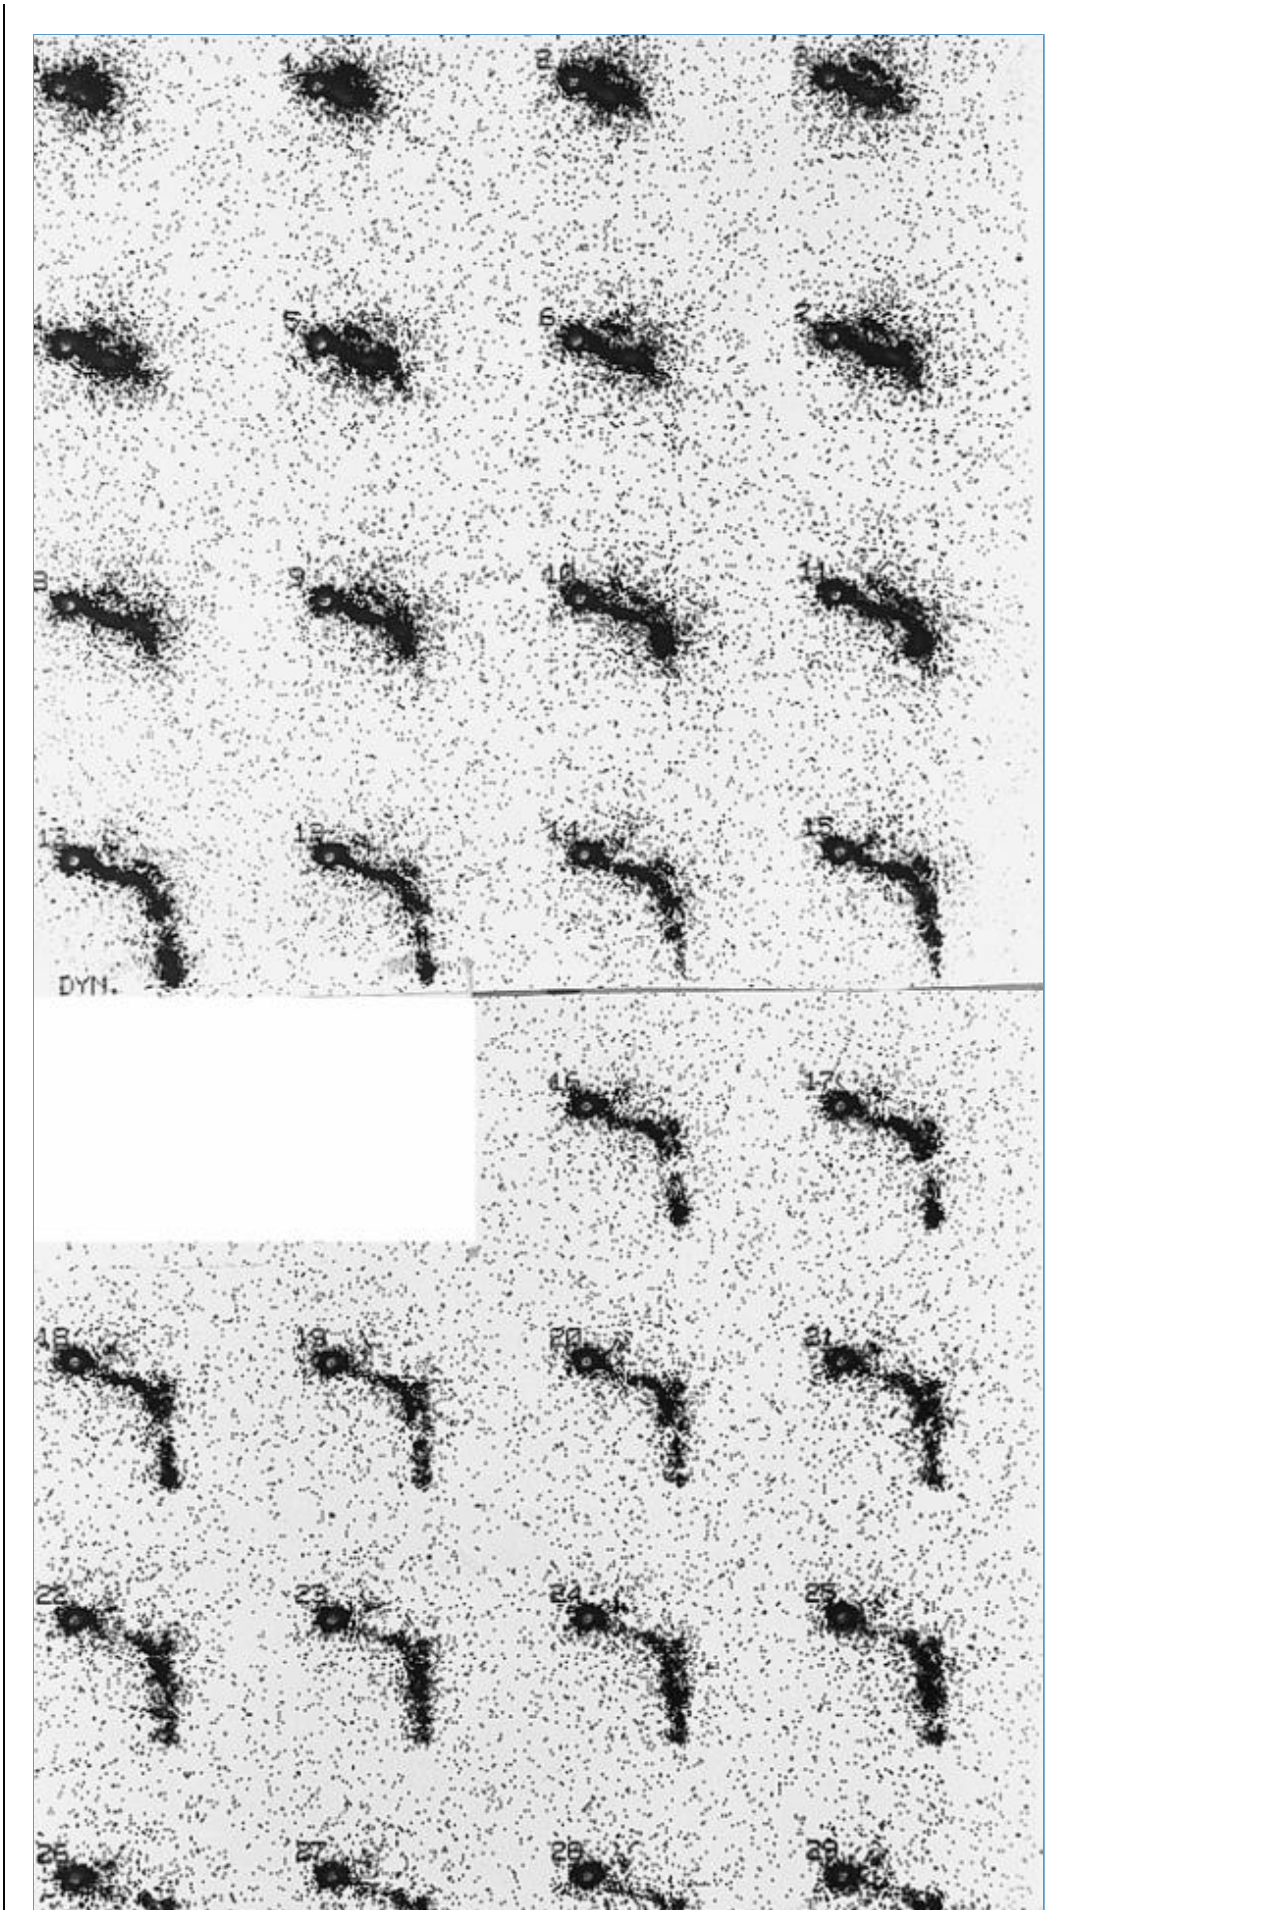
Normal dynamic sequential rhinoscintigraphy.
